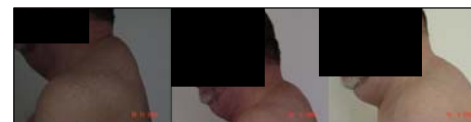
and 3 show the MRI scans and photos of one patient who received 4 mg of r-hGH daily over 12 weeks followed by 2 mg daily. Arrows indicate the different regions of fat assessed. Compared to the large reduction of visceral adipose tissue (VAT) of the abdomen and the dorsovertebral region (buffalo hump), the reduction of peripheral subcutaneous fat (SC) of the face and thigh is relatively small.
